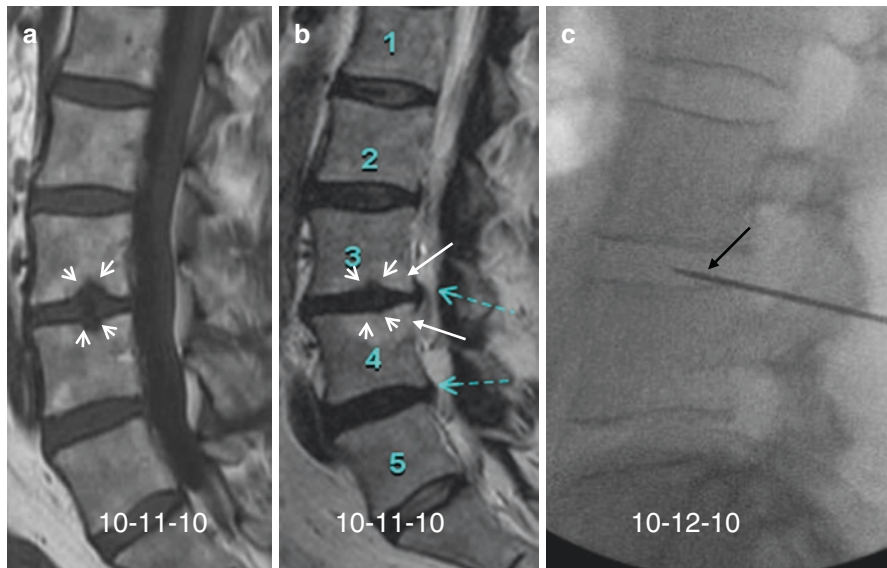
(a–c) Sagittal T1-weighted (a), sagittal T2-weighted (b) and lateral fluoroscopic image from a 56 year old female after injection of a fibrin sealant (Tisseel) done on 08-30-10. The dates are displayed at the bottom of each image. Endplate erosions are seen on both the T1 and T2-weighted MR images (white arrowheads in a and b) and marrow edema is seen adjacent to these erosions on the sagittal T2 weighted image (white arrows in b). Disc bulging at both the L3–4 and L4–5 levels was also present and best seen on the sagittal T2-weighted images (blue dashed arrows in b). The edema was first noted when the patient initially presented with pain less than 6 weeks after injection (white arrows in b). Disc biopsy (black arrow in c) done 6 weeks after the injection showed numerous gram positive cocci. The diagnosis of discitis was made and the patient was treated with intravenous antibiotics
